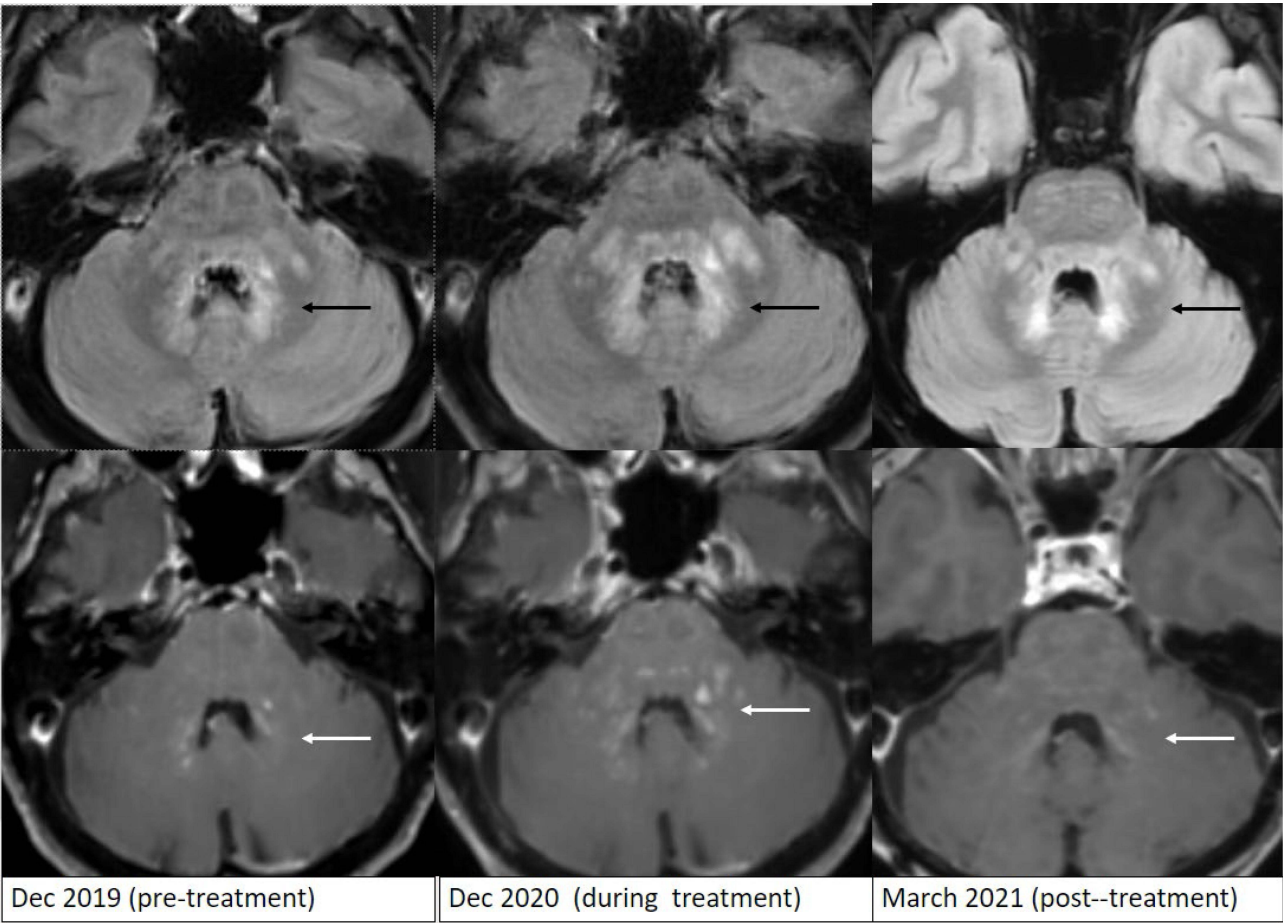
Multiple FLAIR images (top row) and post-contrast T1-weighted images (bottom row) in a 61 year old woman with Erdheim Chester disease obtained before, during and after treatment. Pseudoprogression of edema (black arrow) noted during treatment with associated increase in patchy enhancement (white arrows). Near complete resolution of enhancement and decreased edema noted in the follow up post-treatment MRI.
